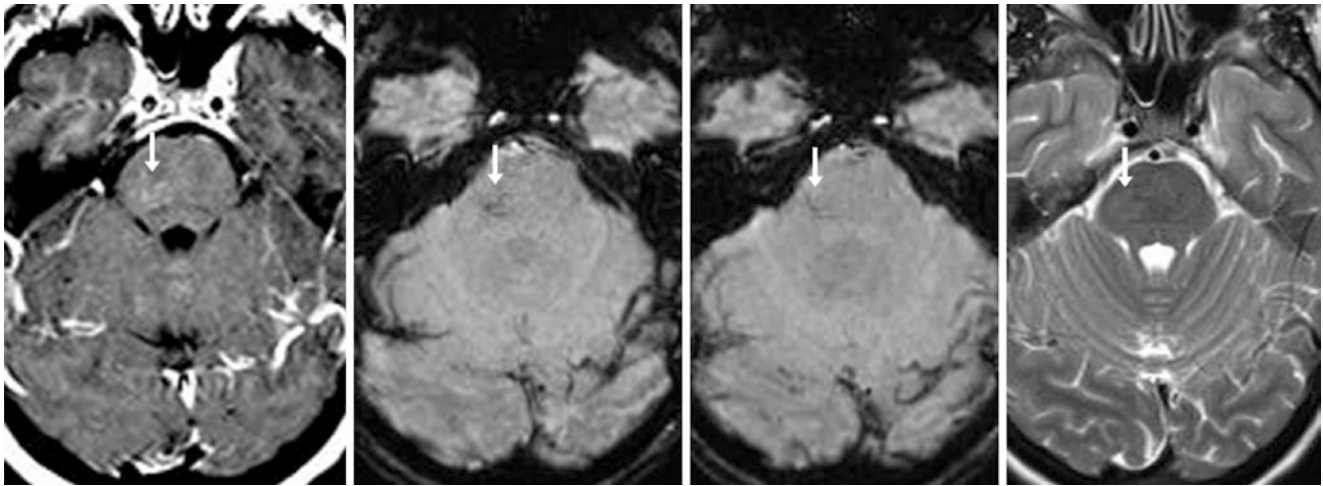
In a 48 year old with gait difficulty an otherwise normal 1.5T MRI demonstrated only faint enhancement of a right pontine BCT (arrows) on postcontrast T1WI (left), with a small vascular tuft on SWIs (left middle and right middle). T2WI (right) and FLAIR (not shown) were normal. This subtle case of BCT could have been missed if SWI had not been obtained
